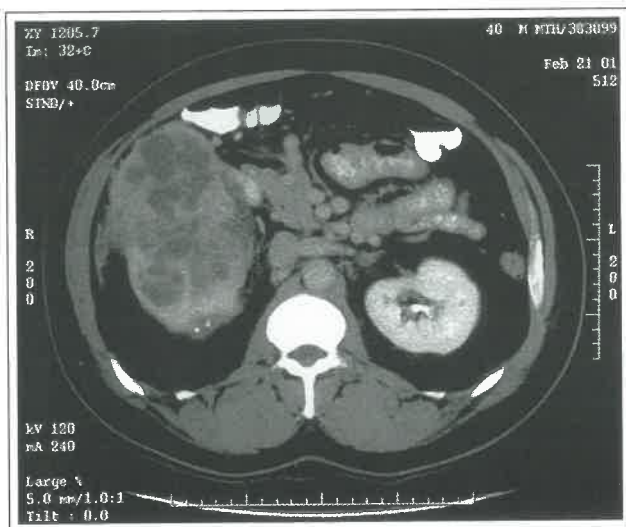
Contrast computed tomography image of a 15 cm right-sided renal tumor removed laparoscopically with intact extraction.
